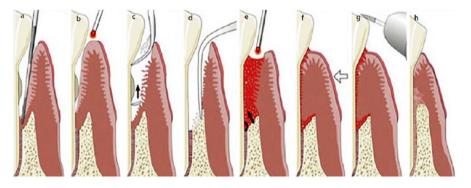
Graphic depiction of LANAP[®] using pulsed Nd:YAG laser. a Bone sounding to determine pocket depth. b Under local anesthesia, a 360 μ m optic fiber delivers 3.6–4.0 W average power at a pulse duration of 100–150 μ s to selectively remove the diseased pocket epithelial lining, denature pathologic proteins and create bacterial antisepsis. c Root surface accretions are removed with piezo ultrasonics and conventional instruments. d Blunt dissection with a conventional dental instrument is used to modify bone contour at the alveolar crest and perform intra marrow penetration to gain access to stem cells and growth factors. e Using the same fiber with a pulse duration of 55–650 μ s, hemostasis is achieved by forming a thick, stable fibrin clot, activating growth factors and upregulating gene expression. f The gin-ate improper contacts and the tooth for approximation. g Occlusal adjustments are performed to eliminate improper contacts and to allow passive eruption. h Predicted healing in an environment conducive for true regeneration of cementum, periodontal ligament, and alveolar bone (LANAP[®] is a patented and registered trademark of Millennium Dental Technologies, Inc., Cerritos, Calif., USA) (Graphic reproduced with permission from Millennium Dental Technologies)
